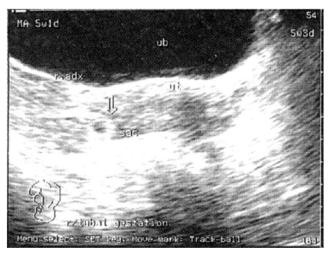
Ultrasonography showing ectopic pregnancy with free fluid in the pouch of Douglas.
